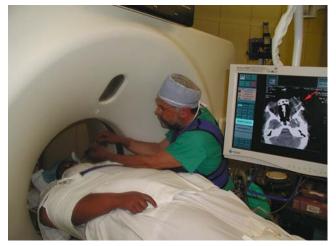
An FNAB procedure performed under CT guidance. Note that the position of the needle can easily be followed on the monitor.
